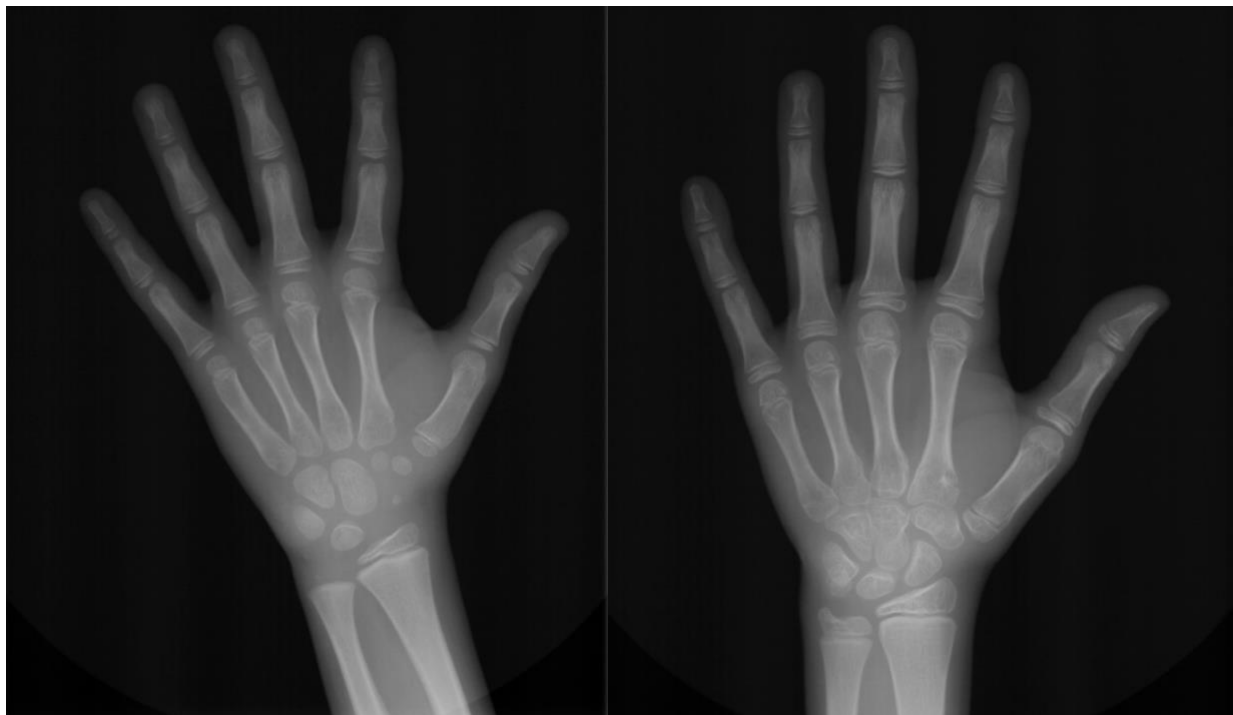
Hand-wrist radiographs of participants of the study
